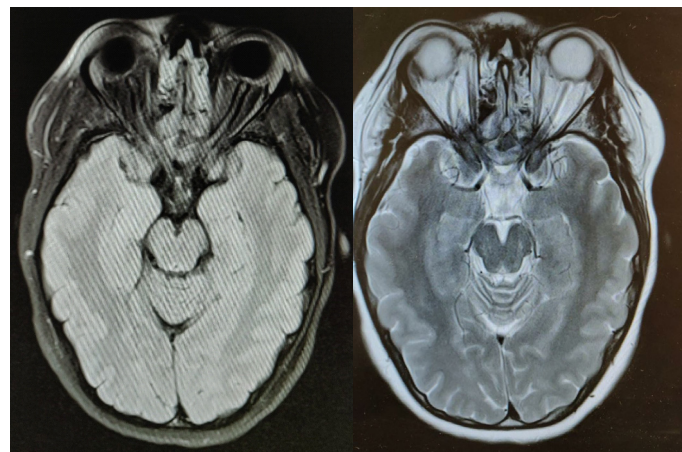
MRI showing prominent subarachnoid space and flattening of posterior sclera.
